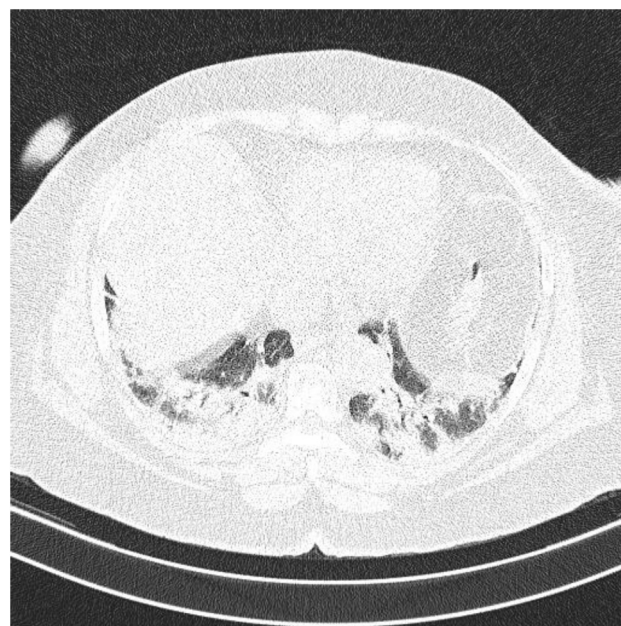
Axial CT scan of the Thorax showing consolidation at both lung bases.
